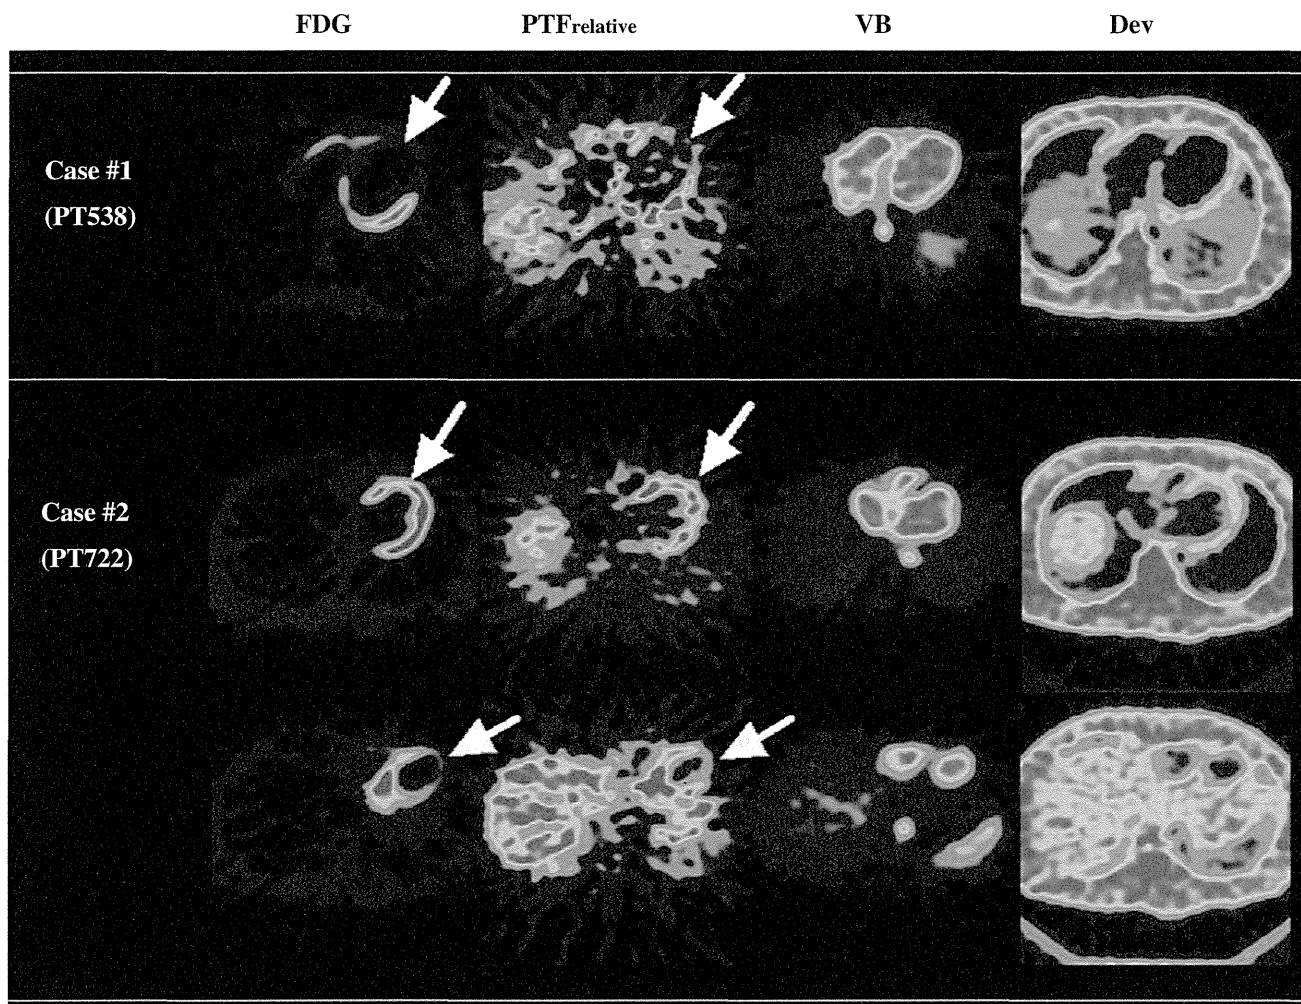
Example images of extra-vascular tissue density (D_{ev}), the blood volume (V_B), ^{15}O -water washout phase (WO, or qualitative PTF), and ^{18}F -FDG uptake, obtained from 2 typical cases. In case 1, the wall motion was irreversible in the anterior wall segment (*arrow, a*), which was well predicted by both WO and FDG as complete
